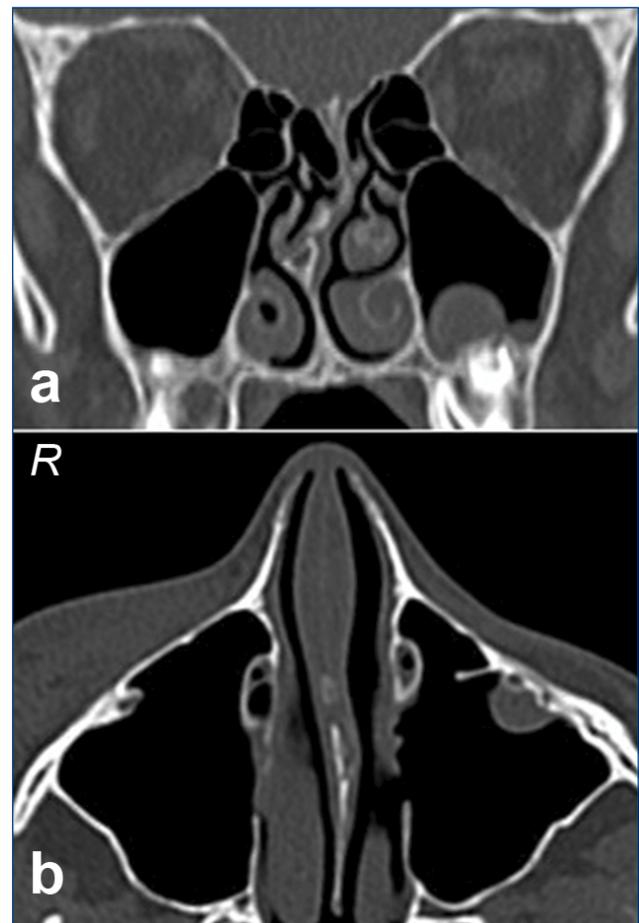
Paranasal CT sections of a 12-year-old girl with a mucus retention cyst and left accessory maxillary ostium. a) coronal section b) axial section
